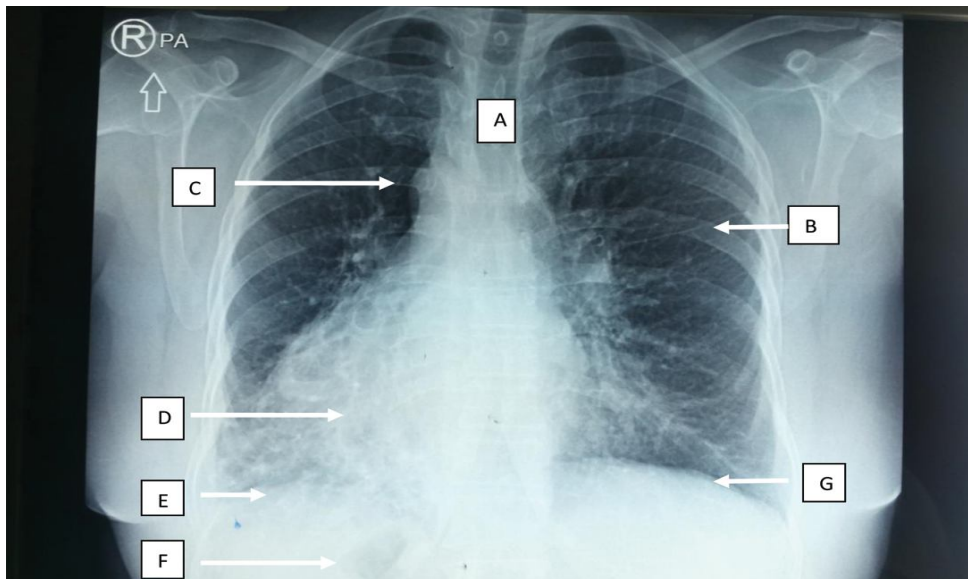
Chest X-Ray PA view showing Trachea (A), Horizontal fissure of right lobe of lung on left side (B), Aortic knob on right side (C), Cardiac apex on right side (D), Left hemidiaphragm on right side which is at a lower level compared to other side (E), Gastric air bubble on right side (F), and right hemi-diaphragm on left side overlying liver (G)
